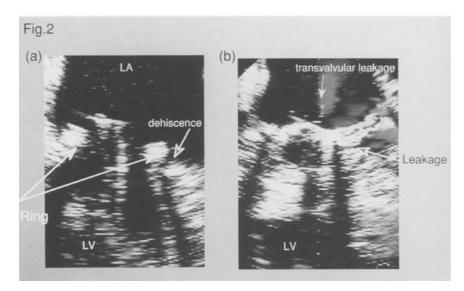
TEE two-chamber views obtained in the longitudinal plane. (a) Both leaflets of the St. Jude mitral valve were in open position during diastole. An echocardiographic artifact obscures the cardiac structures on the left ventricular side of the mitral valve prosthesis. The suture ring of the St. Jude mitral prosthesis was seen at the points indicated (white arrowheads). The dehiscence was also seen at the outside of the ring (gray arrowhead). (b) TEE color-flow imaging of mitral regurgitation at systole. Perivalvular leakage was seen at the points indicated (arrows). LA, left atrium; LV, left ventricle
